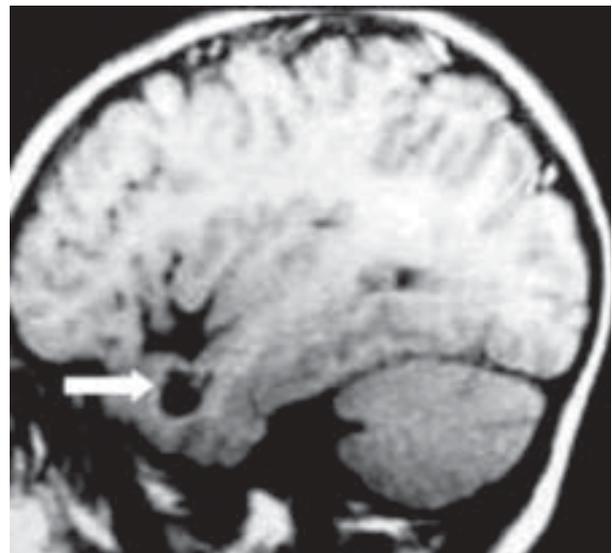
T1 weighted, sagittal MRI of 7-year-old male with one year history of complex partial seizures. Arrow points to low signal mass that was pathologically shown to be an oligodendroglioma.
